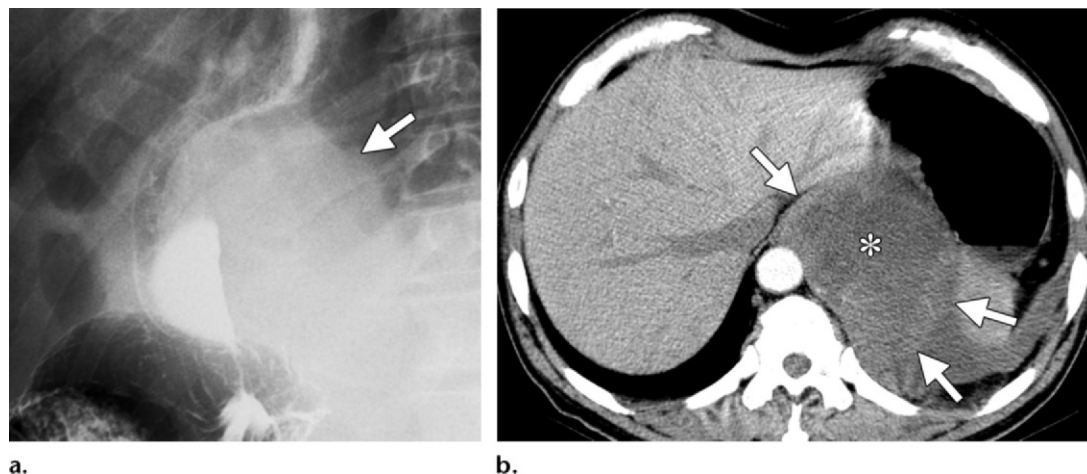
Esophageal GIST in a 65-year-old man with a several-month history of dysphagia and weight loss. (a) Spot image from double-contrast esophagography shows displacement of the distal esophagus by a mass with a prominent exophytic component (arrow). (b) Axial contrast-enhanced CT image shows a large distal esophageal mass (arrows) with central low attenuation secondary to necrosis (*).
